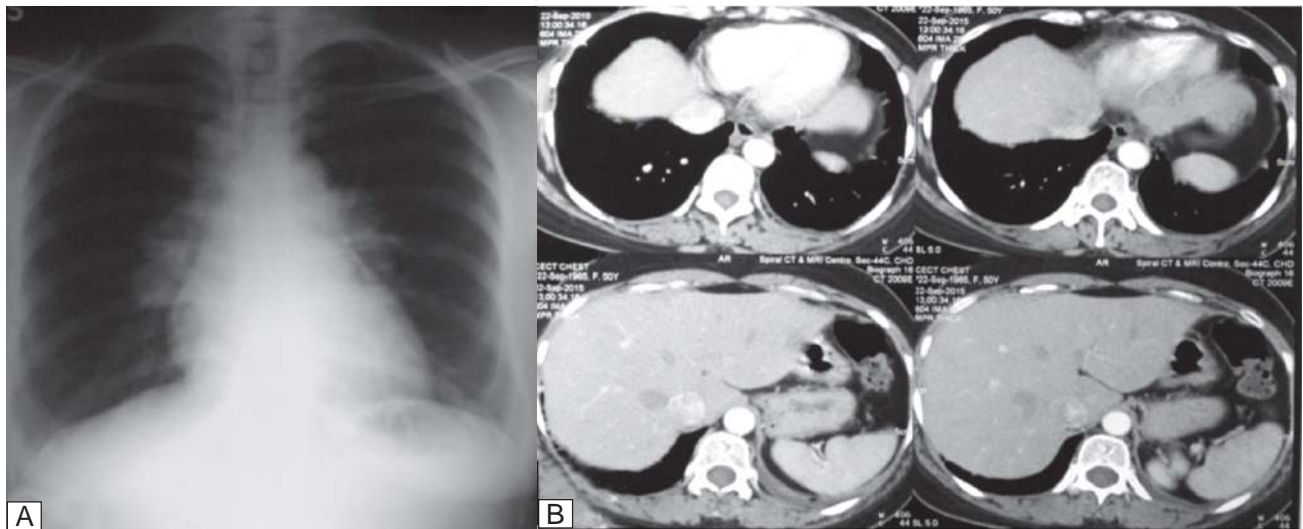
(A) Chest radiograph showing minimal blunting of left costophrenic angle and (B) contrast-enhanced CT chest (axial view) showing mild left pleural thickening.
